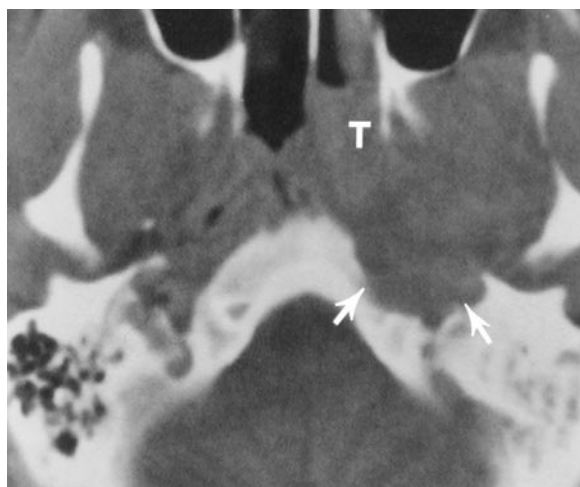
Axial CT scan in a 32-year-old man demonstrates Eustachian tube obstruction and bone erosion (arrows) by nasopharyngeal carcinoma (T) in Rosenmüller's fossa
